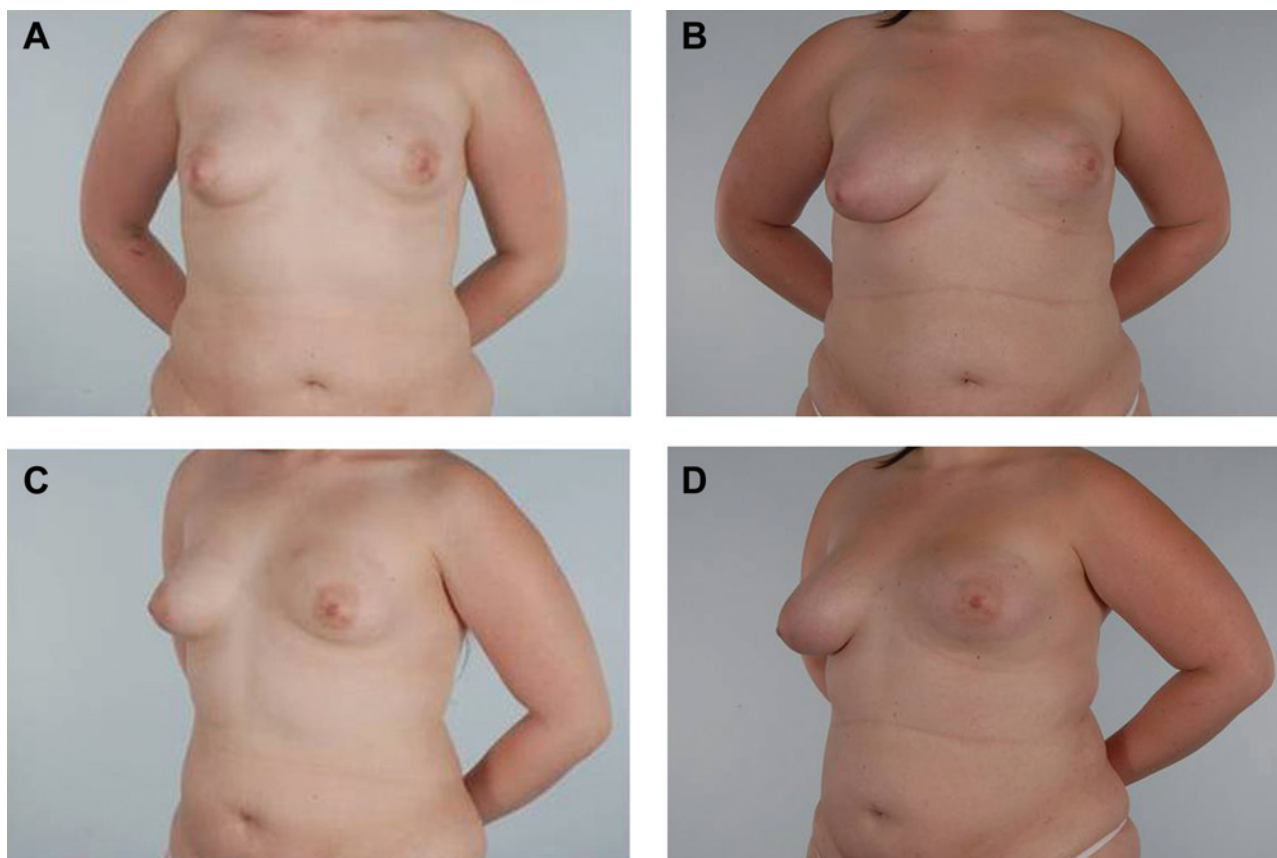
(A, C) This 21-year-old woman presented with severe constriction of the soft tissue envelope of the left breast and desired lipoaugmentation. (B, D) One year after the procedure, in which total lipoaspirate was 1260 cc, yielding 500 cc of graftable fat (40%) with 240 cc of fat injected into the right breast and 260 cc injected into the left. It was not possible to obtain postoperative VECTRA data on this patient due to poor calibration of the images. Magnetic resonance imaging measurements revealed a 77.9-cc volume increase in the right breast and a 77.2-cc increase on the left. This patient was judged as having minimal to no improvement by observers.
